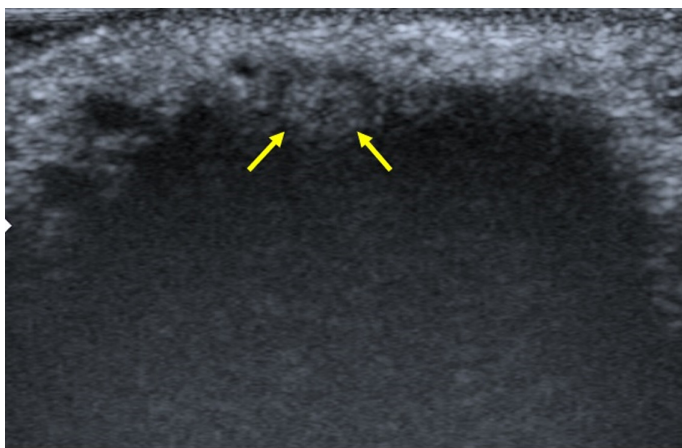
In the gray-scale ultrasound image, the echogenic thrombus material was visible in the superficial dorsal penile vein lumen (arrows).
